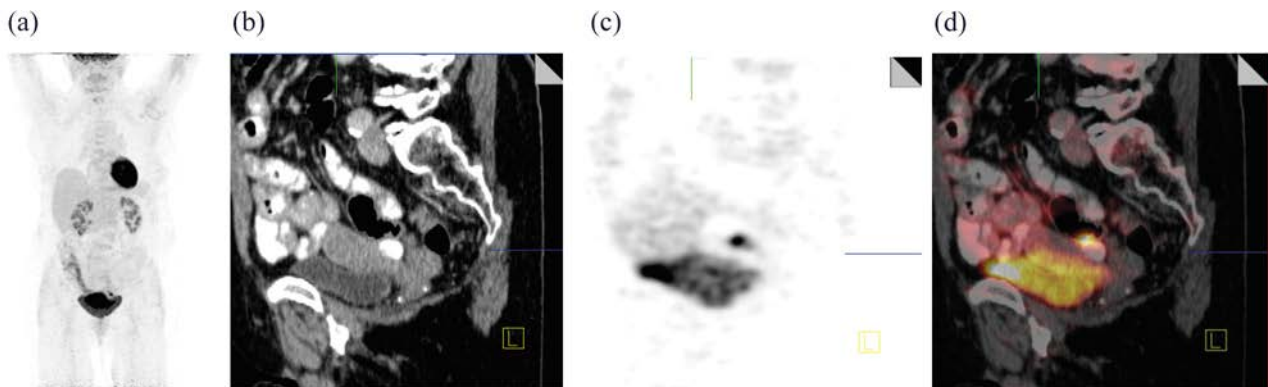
Maximum intensity projection (a), sagittal CT (b), sagittal AC-PET (c) and fused AC-PET/CT (d) demonstrating the change in bladder volume between CT and PET, and subsequent lesion displacement. AC: attenuation corrected.
